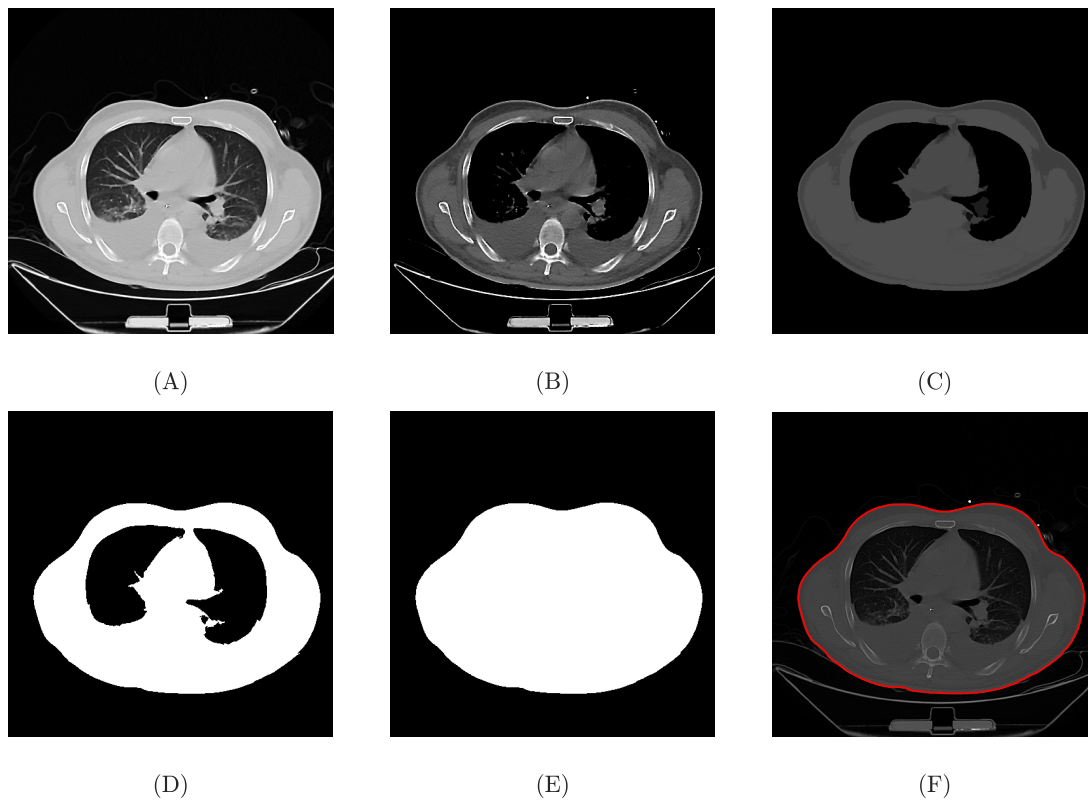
A raw CT image of the 4th intercostal slice (A) was adjusted based on the lung density (B), eroded and reconstructed (C), then binarized (D) and filled to give the final boundary (F).
